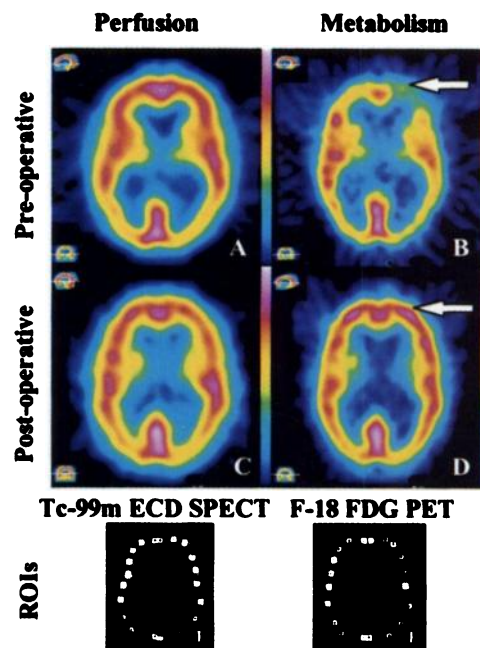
(A) Representative transverse ^{99m}Tc -ECD SPECT and (B) ^{18}F -FDG PET images performed before third ventriculostomy show decreased metabolism relative to perfusion at the frontal lobe on the left side of the patient (arrow). The (C) postoperative ^{99m}Tc -ECD SPECT and (D) ^{18}F -FDG PET images show (D) normalization of metabolism relative to (C) perfusion which, together with functional recovery, indicate viable neurons present in the previously observed areas of mismatch metabolism relative to perfusion (luxury perfusion). The twenty 4×4 -pixel ROIs placed on (A) and (B) are shown in (E) and (F), respectively.
